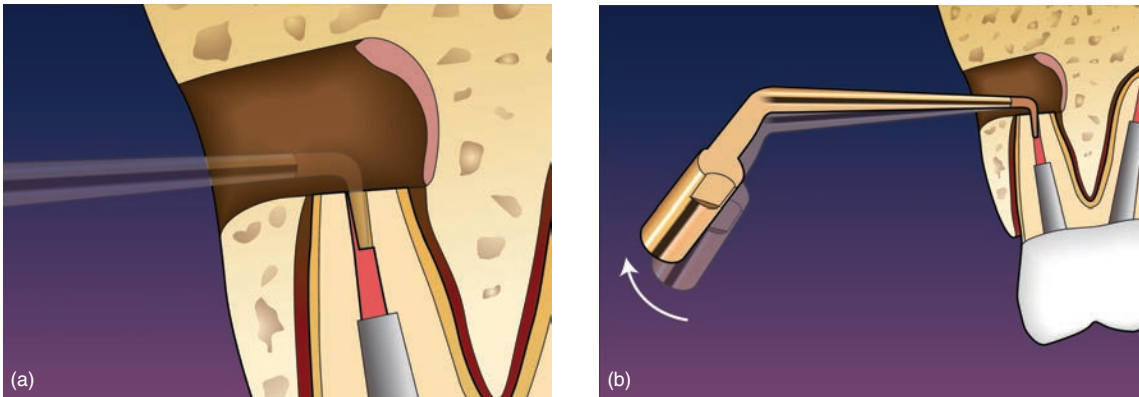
Inspection of root end preparation. (a) A small part of gutta percha is left (arrow) on the buccal wall of the prepared root end cavity. (b) In order to remove this excess gutta percha, the ultrasonic tip can be angled buccally so that the end of the tip will vibrate against the facial wall and gradually loosen the remaining filling material.
